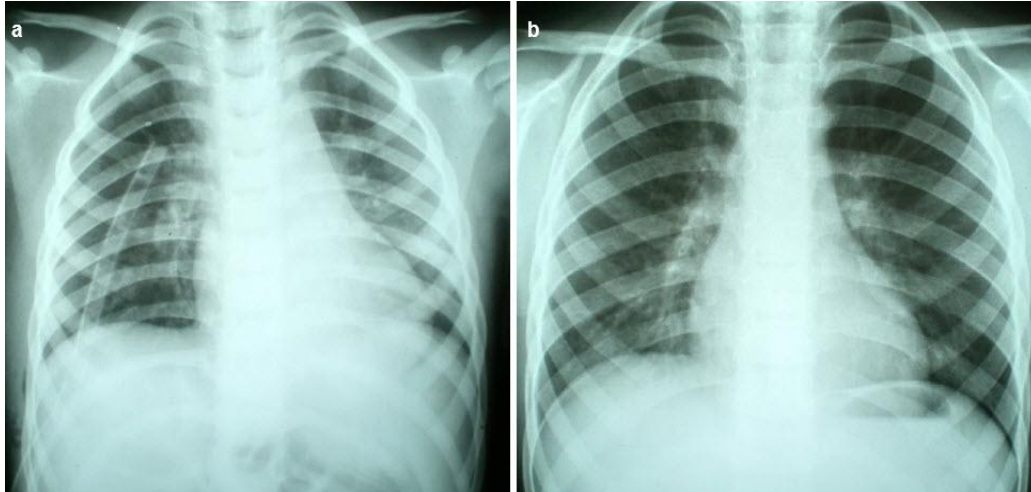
Chest x-ray after primary repair of diaphragmal hernia.
